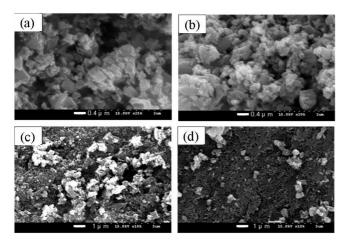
SEM images of Cu-BTCs prepared in various synthesis times by ultrasonic irradiation of reaction mixtures containing solvent of water (4 mL) - ethanol (2 mL) - DMF (1 mL): (a) 1 min (Sample A): (b) 5 min (Sample B): (c) 30 min (Sample C) and (d) 60 min (Sample D). The scale bars for (a), (b), (c) and (d) correspond to 0.4, 0.4, 1 and 1 μ m, respectively.
